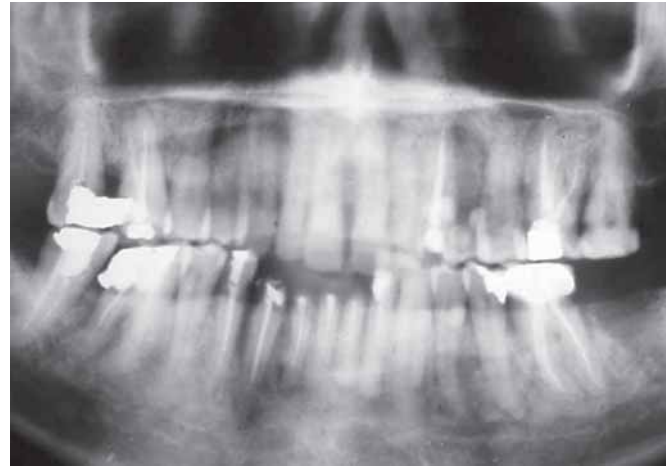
Preoperative orthopantomogram
